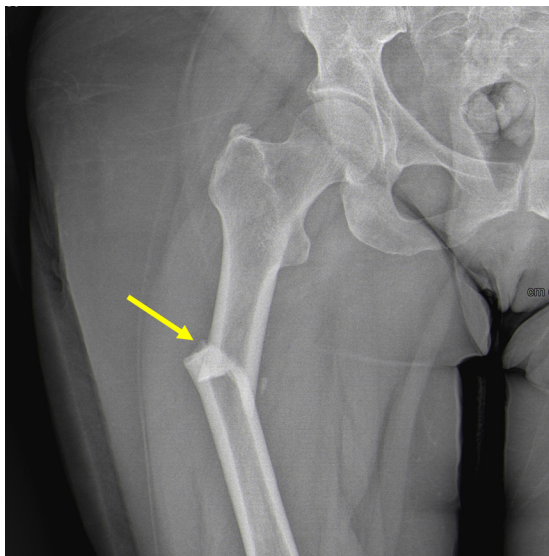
Hip radiograph demonstrates a subtrochanteric fracture (yellow arrow) of the right femoral diaphysis, occurring one year after the scout image shown in Fig. 2.
